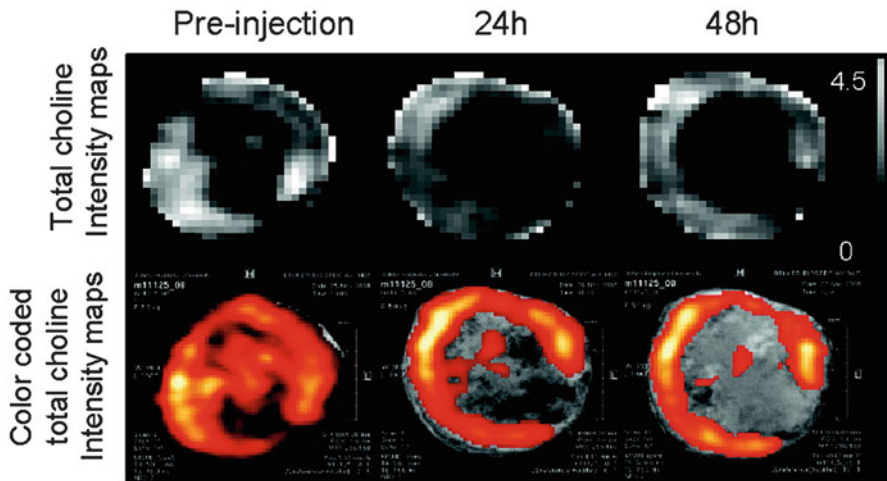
Representative in vivo tCho maps and color coded tCho intensity maps overlaid on corresponding T1-weighted images of a tumor before and at 24 and 48 h after NP injection (300 mg/kg, i.v.) (From Li et al. 2010)
